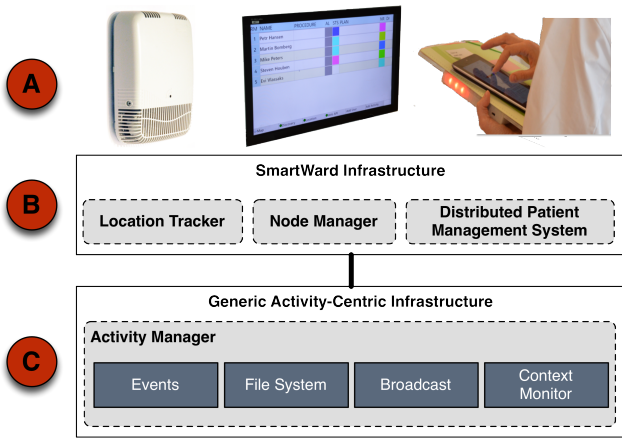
The HyPR infrastructure (B) is a distributed context-aware infrastructure designed to support multi-device location-aware collaborative workflows in patient wards. The infrastructure uses an ultrasound location tracker for location-aware services (A) and is built on top of a general purpose activity-centric infrastructure [10] (C).
